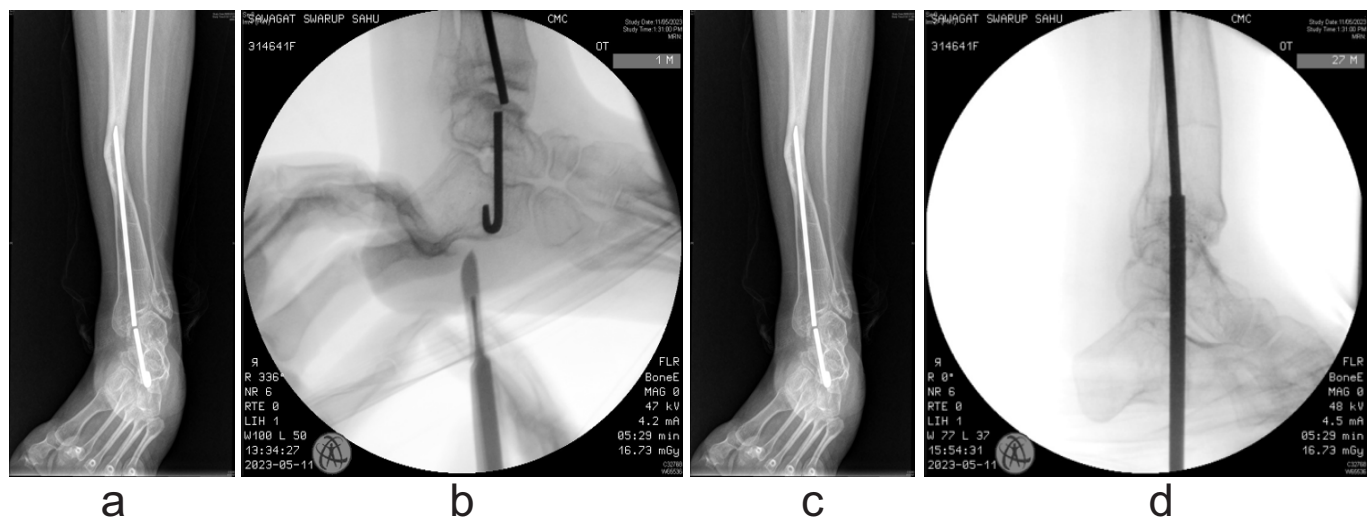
(a) Pre op X-ray lateral. (b) Intra-op. (c) Anterior posterior X-ray. (d) Pre-op image.
